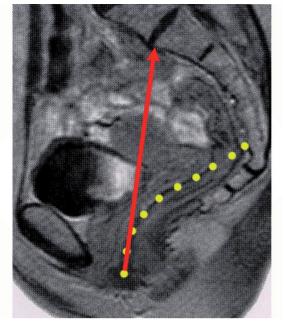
MRI – Picture of the female pelvis in upright position. Sagital view of pelvic organs.Dotted yellow line = normal axis of vagina in a banana shaped backwards curveRed arrow = unphysiological vertical unbowed axis of vagina after laparoscopic/laparotomic sacrocolpopexy.
